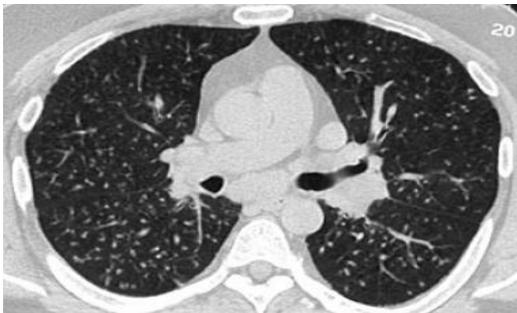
Showing HRCT of the same patient with multiple small nodules in a case of Miliary tuberculosis.
